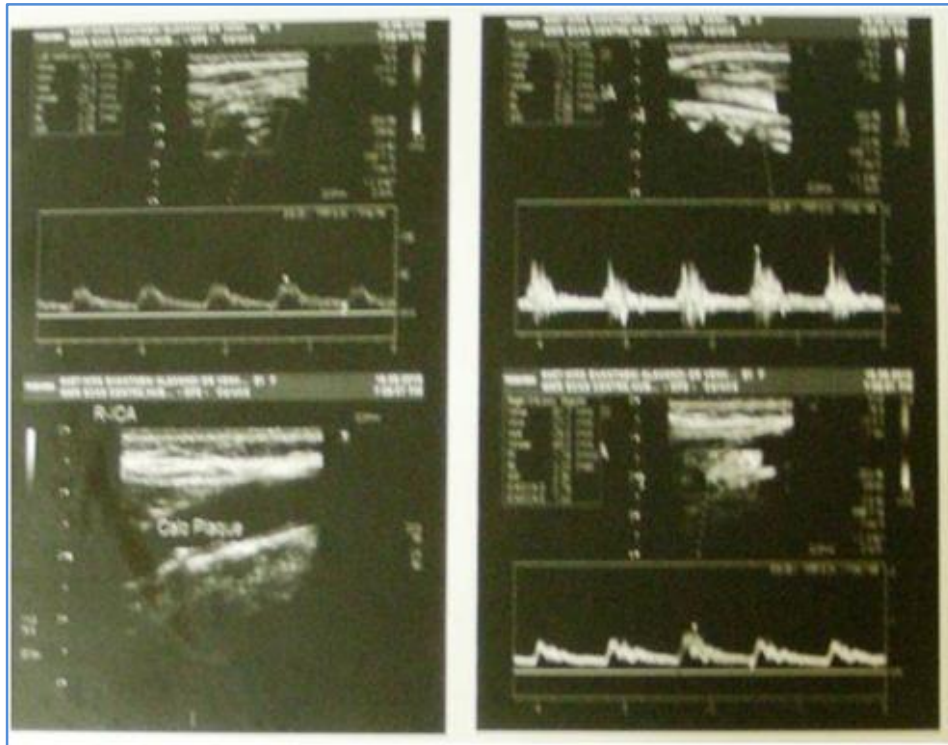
Ultrasonographic image showing small calcified plaque at right carotid bifurcation
